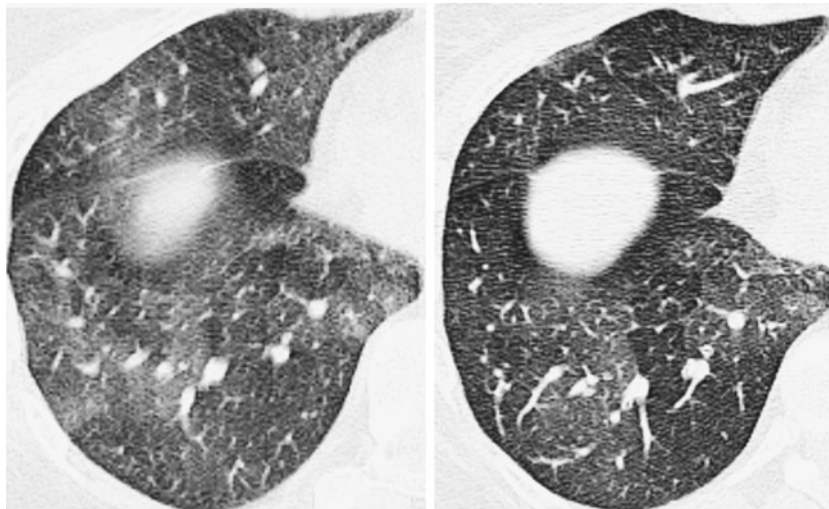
Longitudinal CT findings in a 33-years old double lung transplant recipient with progressive air trapping whose allograft dysfunction did not respond to azithromycin therapy. Two axial thin-slice CT imaging at end-expiration before (*left*) and after (*right*) treatment with azithromycin in a patient who did not respond. The pre-treatment CT image demonstrates some secondary pulmonary lobules with air trapping. The follow-up CT image on the right
